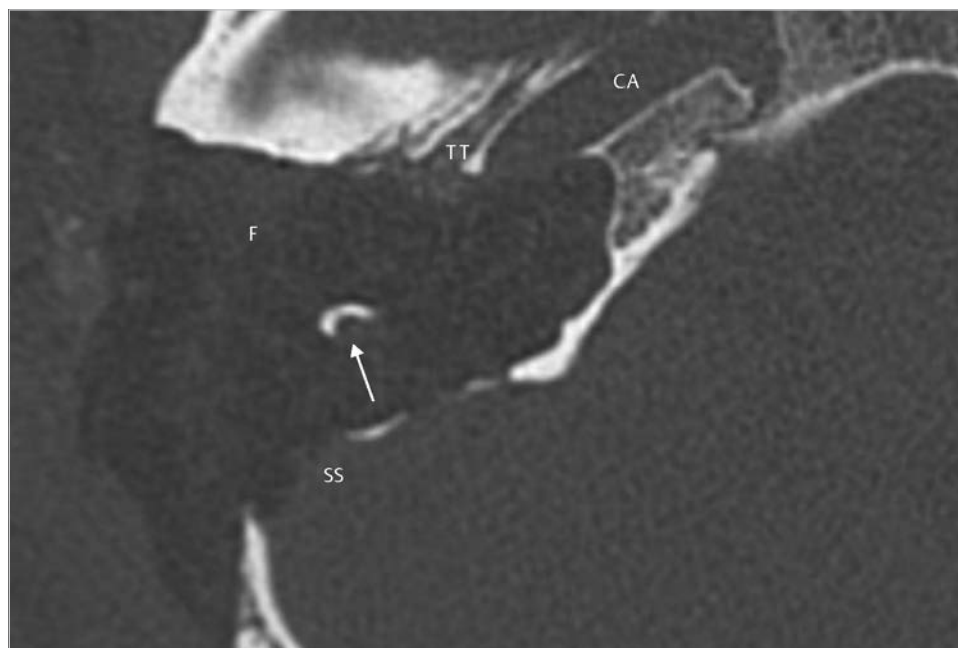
Postoperative CT shows extensive removal of bone from the petrous apex. The mastoid segment of the facial nerve is left in the fallopian canal (*arrow*). The posterior fossa dura is partially exposed, and the carotid artery is uncovered posterolaterally. CA, carotid artery; F, abdominal fat; SS, sigmoid sinus; TT, tensor tympani.
